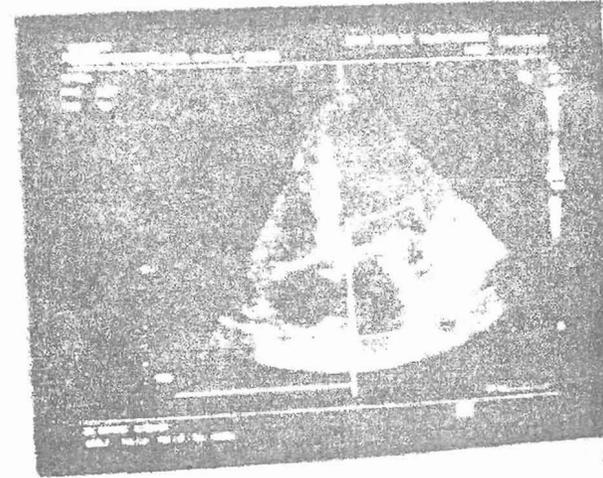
Parasternal Long Axis of a 16 year old Female Patient with Heart Failure
